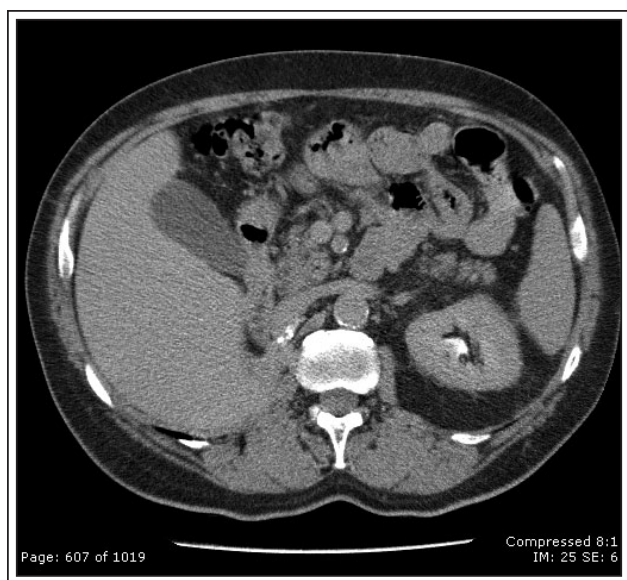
Follow up CT scan showing no suspicious lesion.
